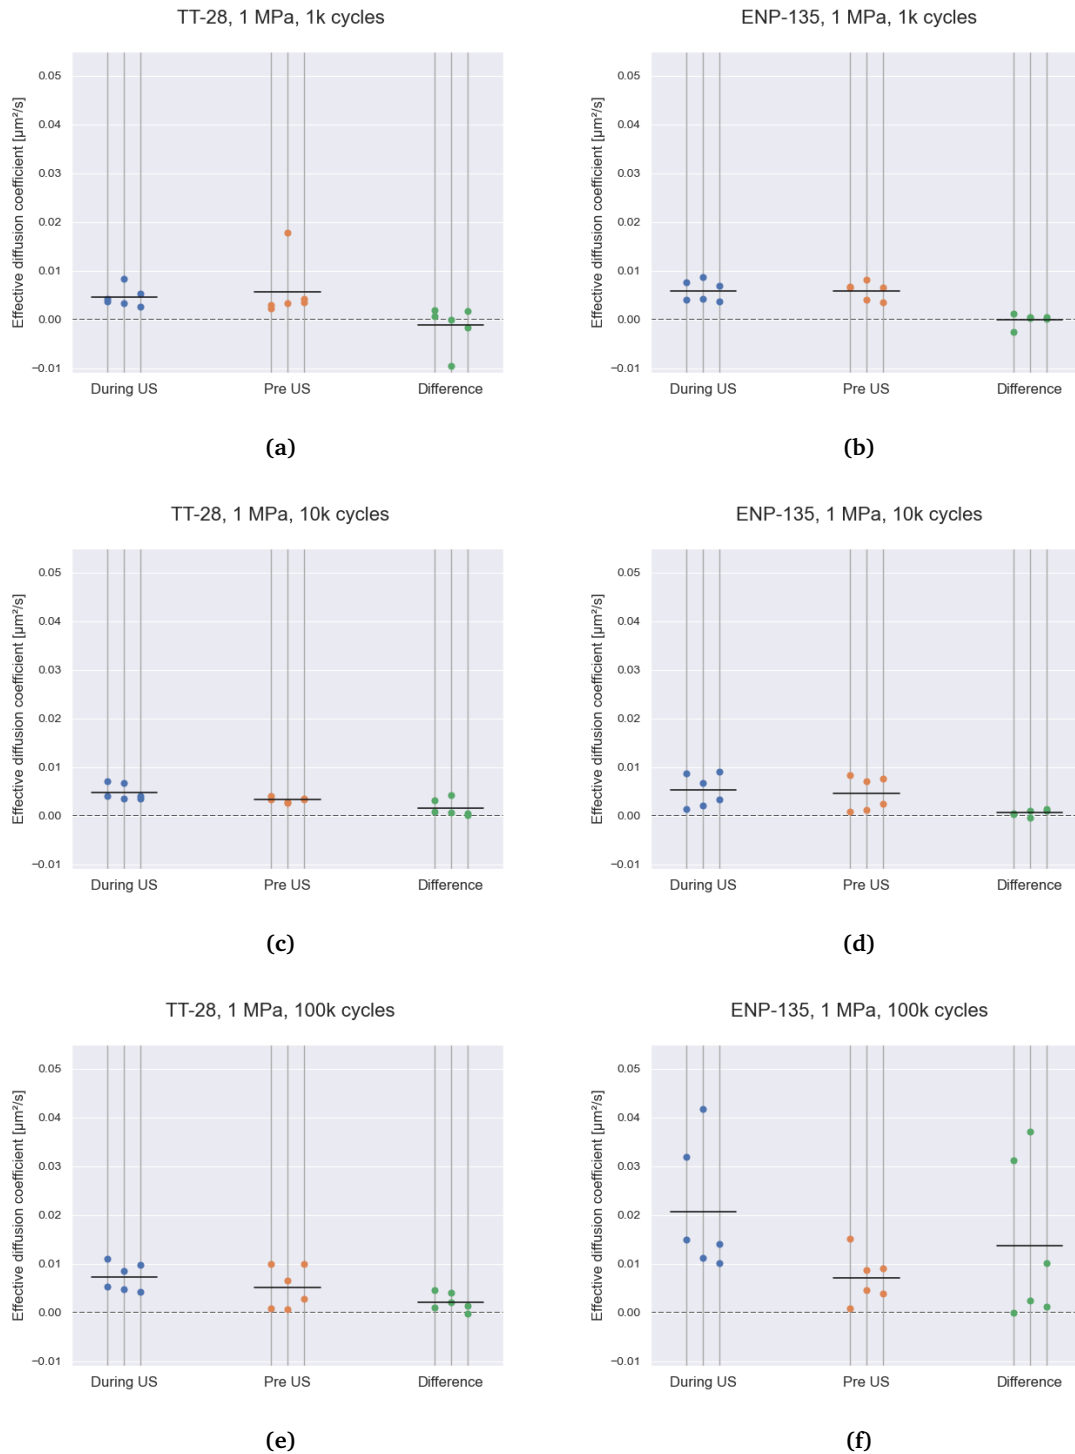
The measured effective diffusion coefficient at 1 MPa peak negative pressure, and at varying duty cycles. Results pre- and during ultrasound exposure for each measurement location are shown, as well as the difference between them. The three vertical tracks within one group represents from left-to-right the first, second, and third ultrasound treatment of each sample. The black line represents the mean of all 6 measurements in that group.
